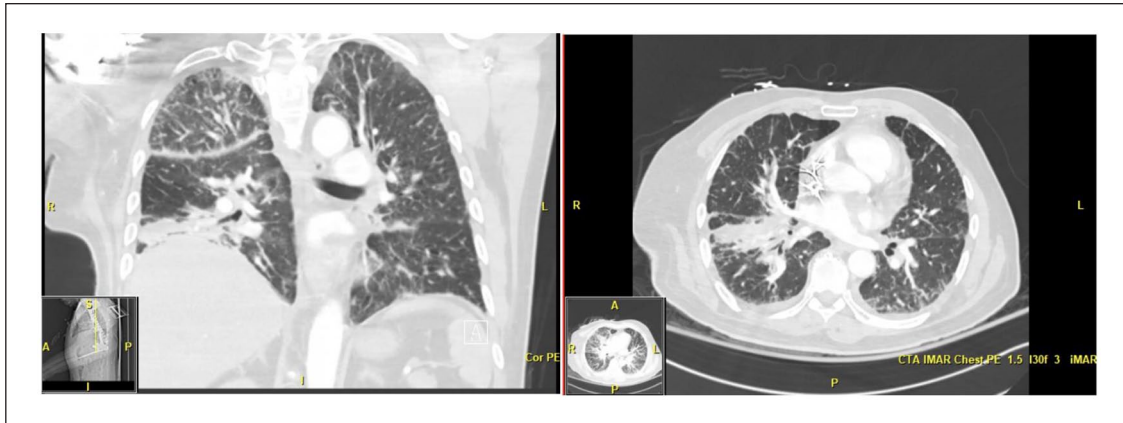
Coronal and transverse CT with contrast images of lung demonstrating subsegmental right lower lobe atelectasis with volume loss in the right hemithorax and asymmetric right greater than left diffuse interlobular septal thickening. Asymmetric lymphangitic carcinomatosis could present with a similar appearance.
